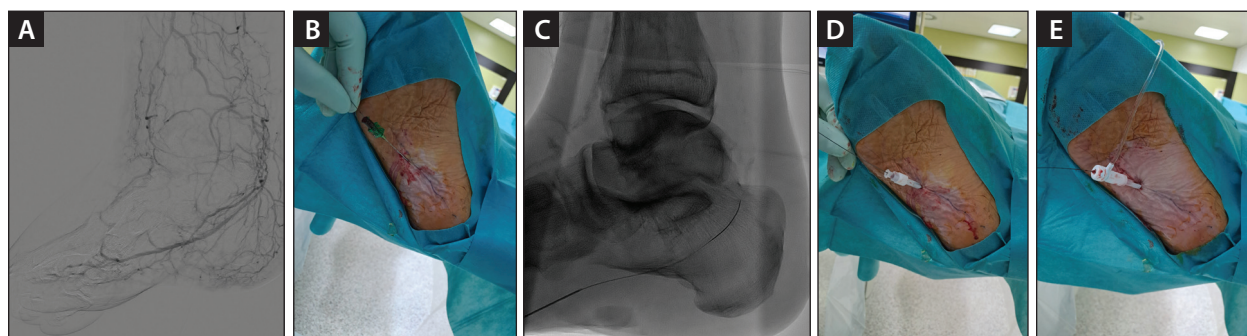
Digital subtraction angiogram of right foot in lateral projection showing occlusion of the distal PT artery and proximal common plantar artery (A). Image obtained after ultrasound-guided puncture of the lateral plantar artery from a plantar approach with needle and guidewire in place (B). Fluoroscopic image showing the needle and guidewire in the lateral plantar artery (C). Image after insertion of sheath and dilator of pedal access set (D). Image after placement of hemostatic valve of pedal access set (E).
